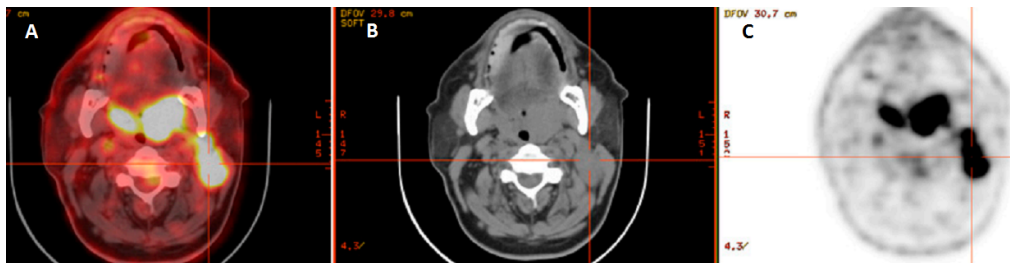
The first figure(A),integrated an head and neck cancer image from a PET/CT scanning. Figure(B), shows the image from a CT scanning. Figure(C) shows the image from a PET scanning, [33]. The primary cancer location is found in the center of the red line on all three images.
